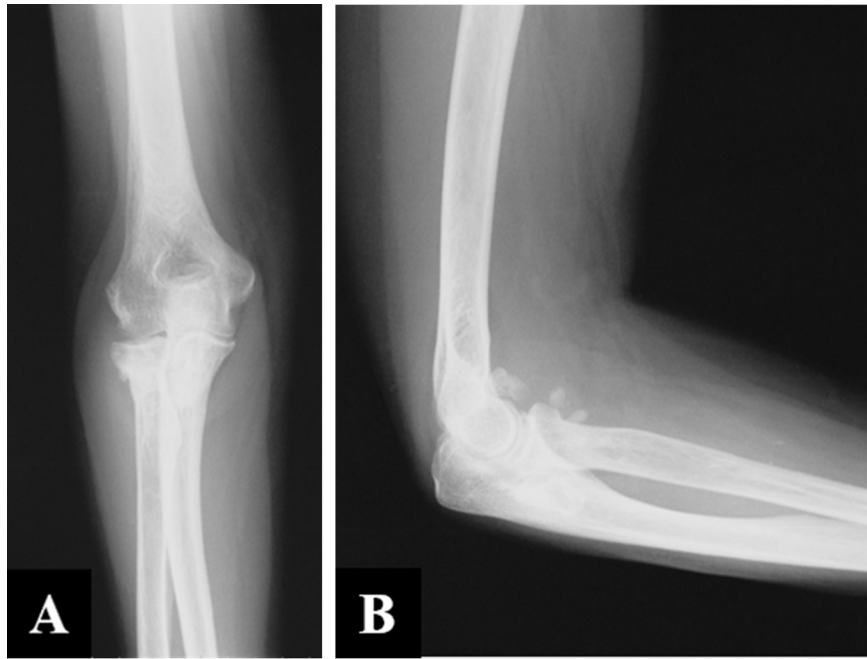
Anteroposterior (A) and lateral (B) roentgenograms of the right elbow at 8 years before our operation show osteoarthritis with calcareous depositions on the anterior side of the elbow joint.
